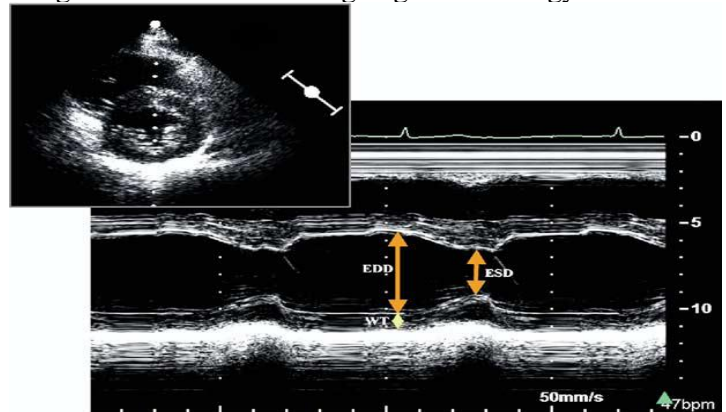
Measurement of left ventricular end-diastolic diameter (EDD) and end-systolic diameter (ESD) from M-mode, guided by parasternal short-axis image (upper left) to optimize medial-lateral beam orientation (8).
